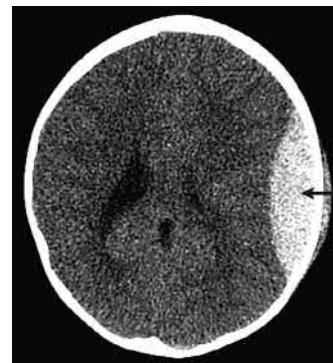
CT scan of head showing a left extradural haemorrhage (arrow).
